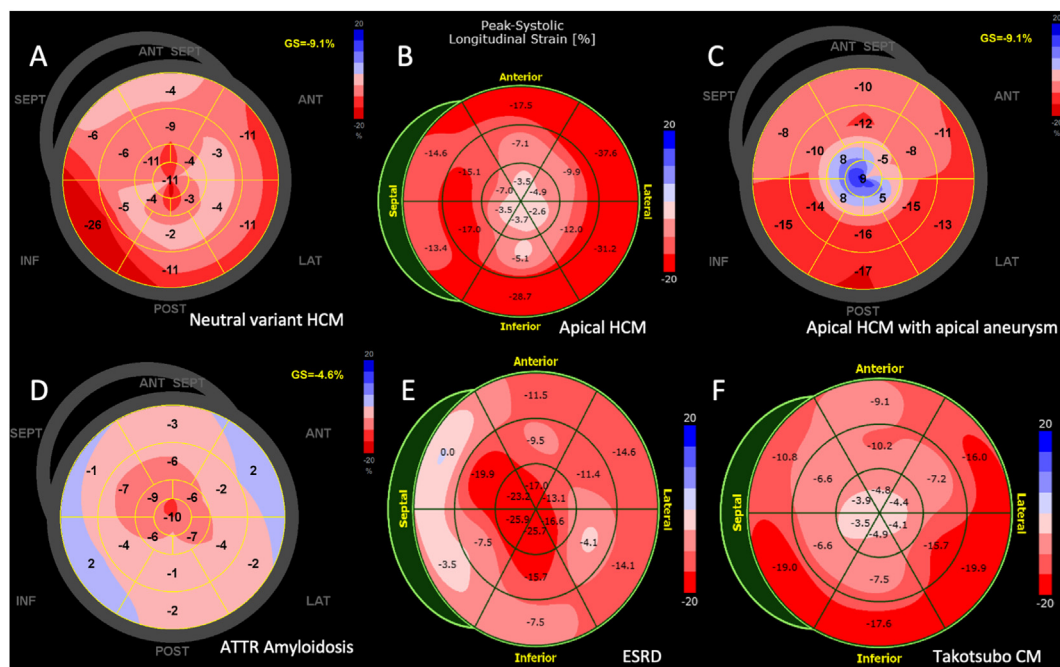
Use of LV strain patterns to determine etiology of LV hypertrophy and HF. Despite the common 2D echocardiographic LV morphology of LV wall thickening, the strain maps show particular patterns suggestive of (A) neutral-variant HCM with relatively impaired septal function, (B) apical HCM demonstrating apical impairment, (C) apical HCM with apical aneurysm demonstrating apical dyskinesia, (D) transthyretin cardiac amyloidosis demonstrating a relative apical-sparing pattern, (E) end-stage renal disease (ESRD) with a pattern mimicking a relative apical-sparing pattern, and (F) takotsubo cardiomyopathy (CM) with impairment of the mid to apical segments but sparing of the basal segments. ANT, Anterior; ANT_SEPT, anteroseptal; GS, global strain; INF, inferior; LAT, lateral; POST, posterior; SEPT, septal.
